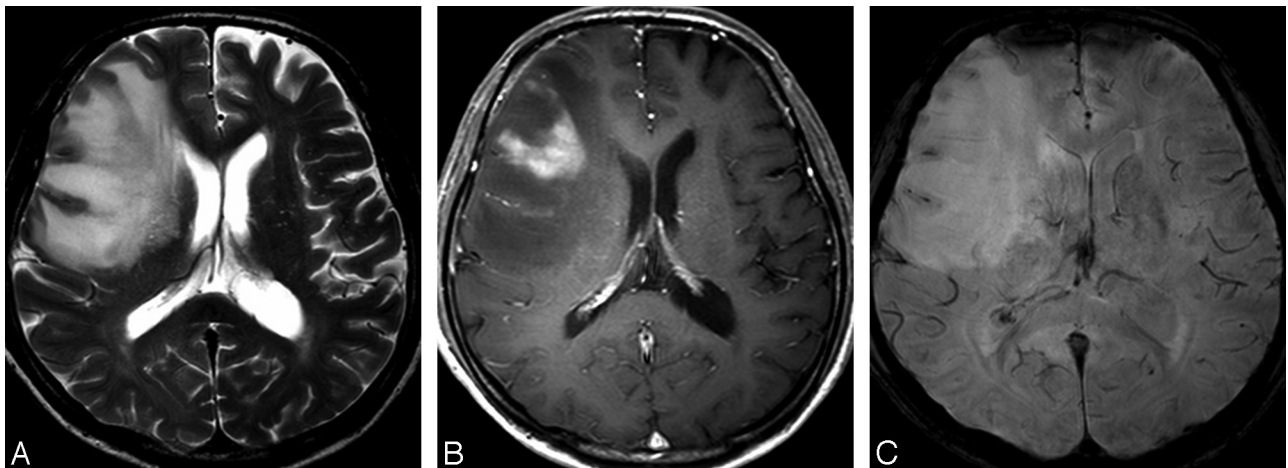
MR images of a 45-year-old man with lymphoma. *A*, The axial T2-weighted image shows an ill-defined mass with high signal intensity in the right frontal lobe. *B*, The contrast-enhanced axial T1-weighted image shows the mass with peripheral enhancement. *C*, No evidence of an ITSS (grade 1) is seen within the mass on HR-SWI.
